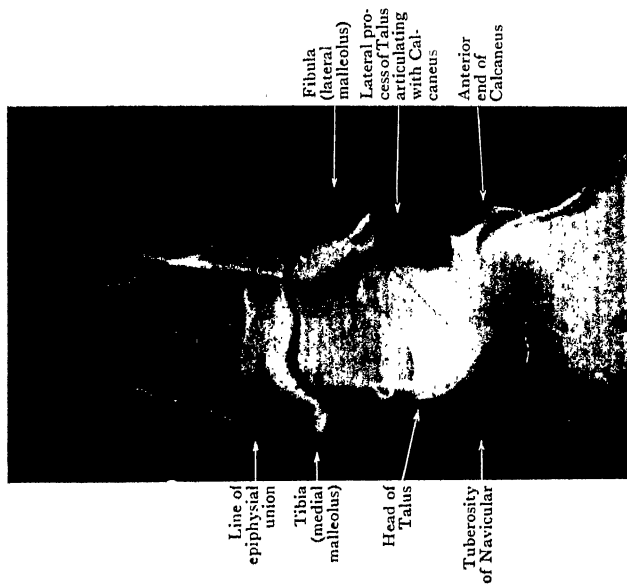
Antero-posterior Radiograph of Ankle and Tarsus of young man aged 22. Note that the superimposition of the tarsal bones makes it difficult to distinguish them. Cf. Fig. 187B.
